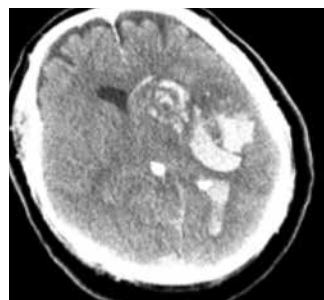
Repeat head CT five hours after tPA administration for treatment of pulmonary emboli and ischemic stroke.
